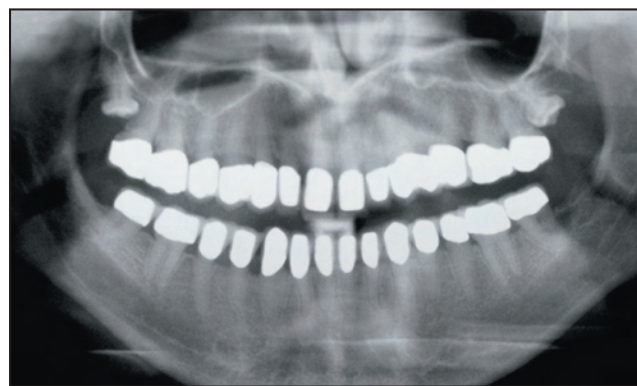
Panoramic radiograph 1 year later.
